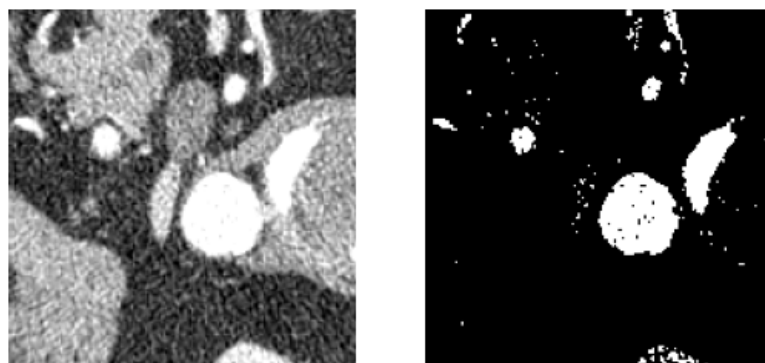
Raw CTA before and after the thresholding. (Patient 1)
